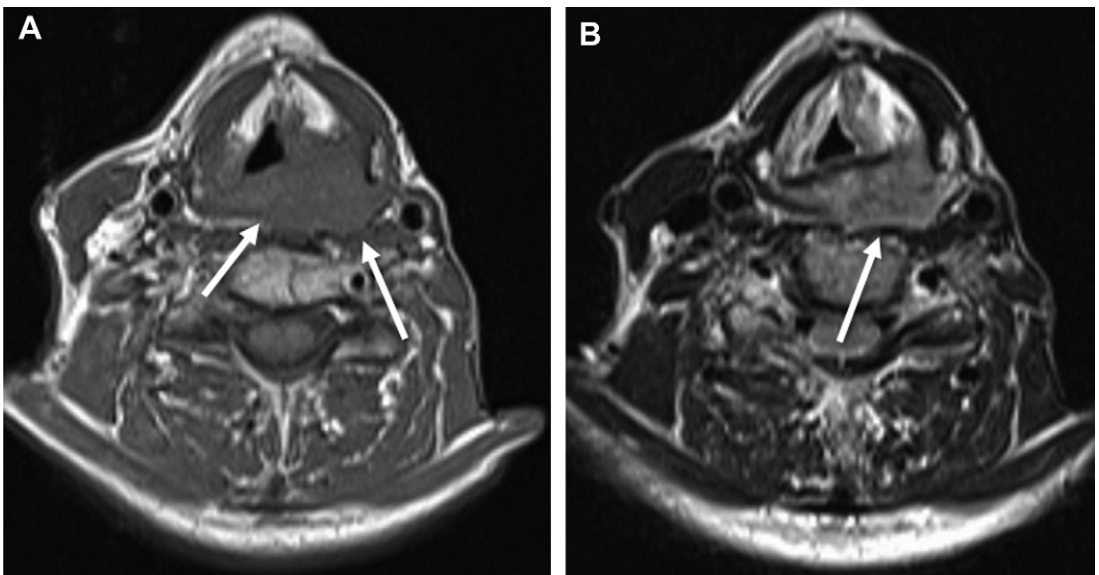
Laryngohypopharyngeal SCC with preoperative imaging suggesting prevertebral fascia invasion. (A) T1-weighted axial image shows apparent obliteration of fat in the retropharyngeal space (*arrows*). (B) T2-weighted axial image at the same level shows loss of fat in retropharyngeal space but smooth interface between posterior aspect of tumor and prevertebral muscles (*arrow*). At surgery the fascia over prevertebral muscles was intact and the tumor was completely resected.
